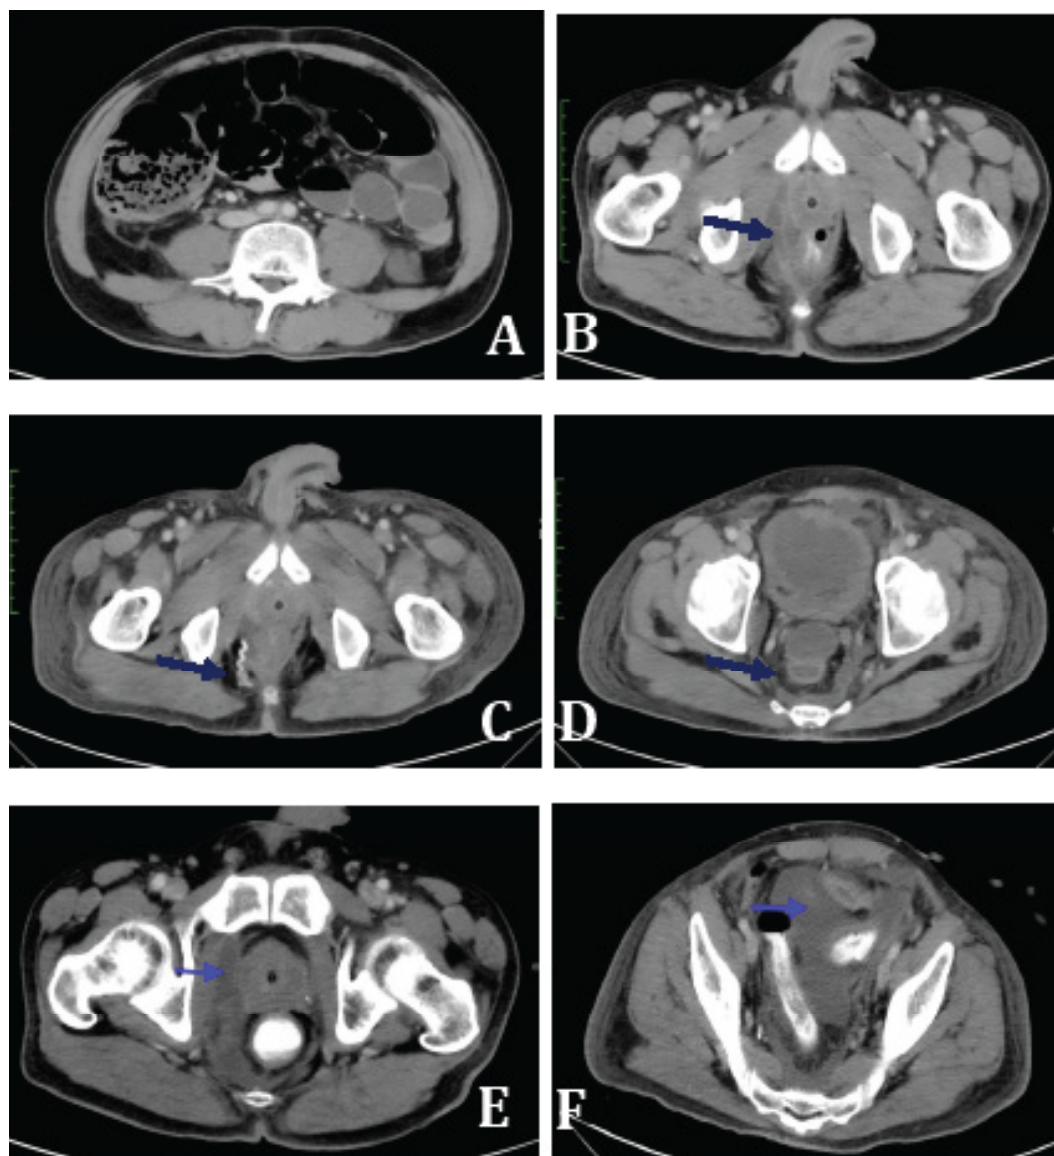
Axial images of CT Abdomen and Pelvis for Patient A. CT performed after noted persistent purulent discharge from the perianal incision. Perianal abscess collection extends into the pelvis and leaves the paracolic region, as demonstrated by blue arrows (A and B). CT- guided approach to drain the intraabdominal collections (C). Resolution of collections prior to hospital discharge (D).
